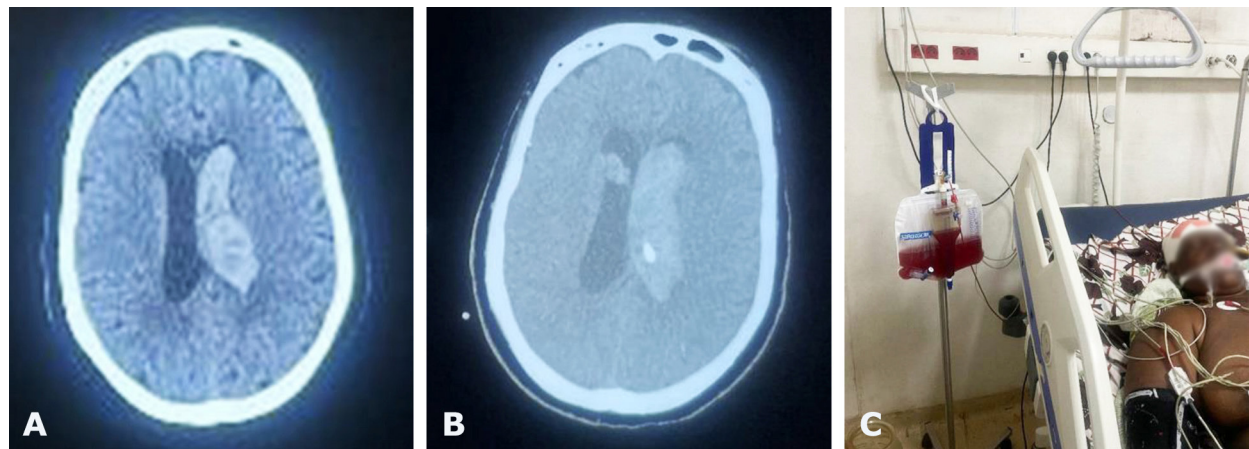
Preoperative CT scan showing IVH (A), postoperative CT scan showing intraventricular location of the catheter tip (B) and photograph of Patient with EVD in-situ ICU (C)
